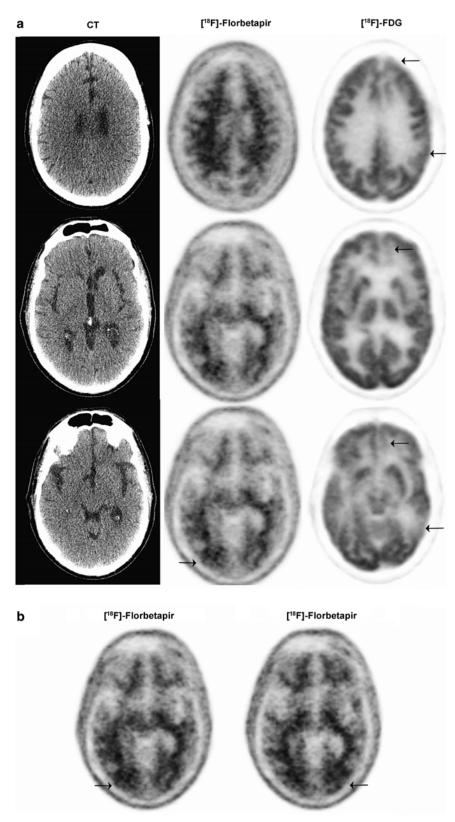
Imaging from a 59-year-old, physician with a sports-related injury (case 2). [¹⁸F]-Florbetapir PET imaging findings were negative for amyloid accumulation except for focal [¹⁸F]-Florbetapir retention at the site of impact in the occipital region (arrows). (a) CT (left panel) [¹⁸F]-Florbetapir PET (middle panel) and FDG PET (right panel) at various depths of the brain. (b) [¹⁸F]-Florbetapir PET indicating amyloid accumulation. CT, computed tomography; FDG, [¹⁸F]-fluorodeoxyglucose; PET, positron emission tomography.
